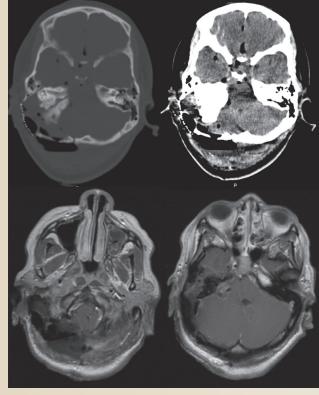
Stage one: Posterior fossa far lateral craniotomy with partial mastoidectomy. (Top) Axial CT images in bone and soft tissue algorithms. (Bottom) Axial T1 postcontrast images. Tumor is still seen extending into the hypoglossal canal.
